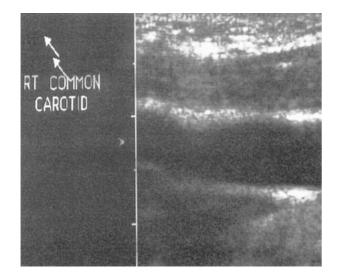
Ultrasound scan of right neck vessels; no arterial dissection or haematoma evident.
